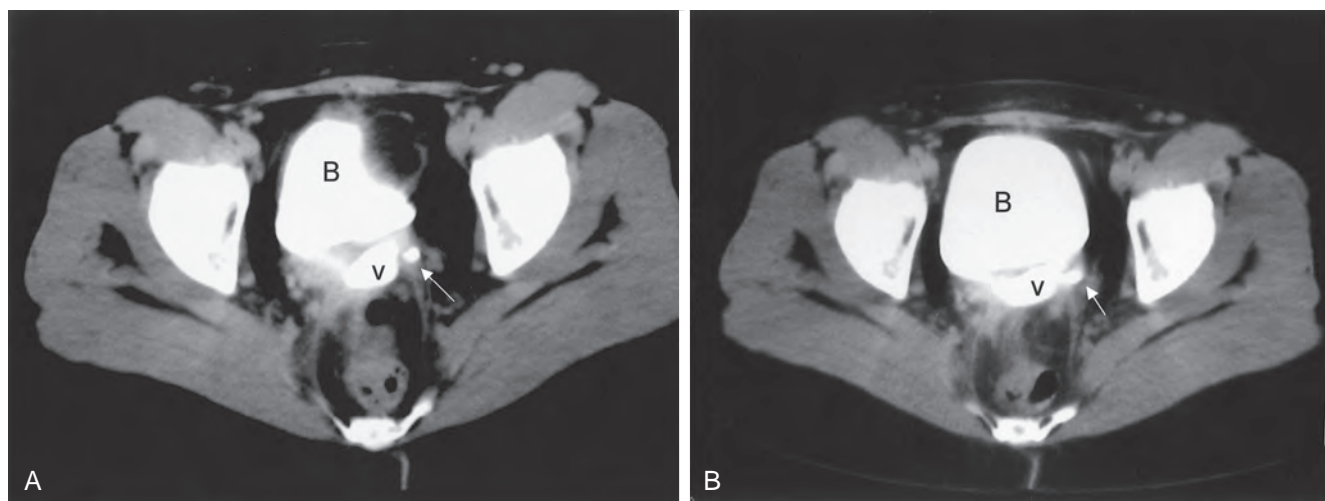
Computed tomography (CT) scan of ureterovaginal fistula. A, CT scan demonstrates contrast material within the bladder (B) and vagina (v). The ureter is visible (arrow) adjacent to the vagina. B, This image shows the ureter (arrow) entering the vagina.
